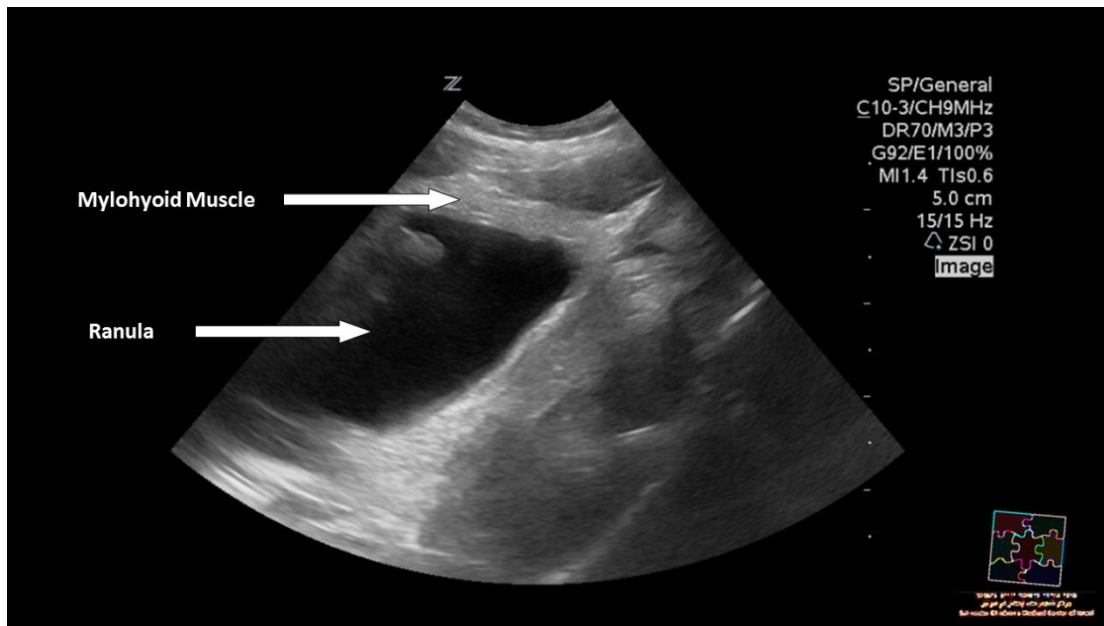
The ultrasonographic image, demonstrating the isolated ranula without extravasation through the mylohyoid muscle.
